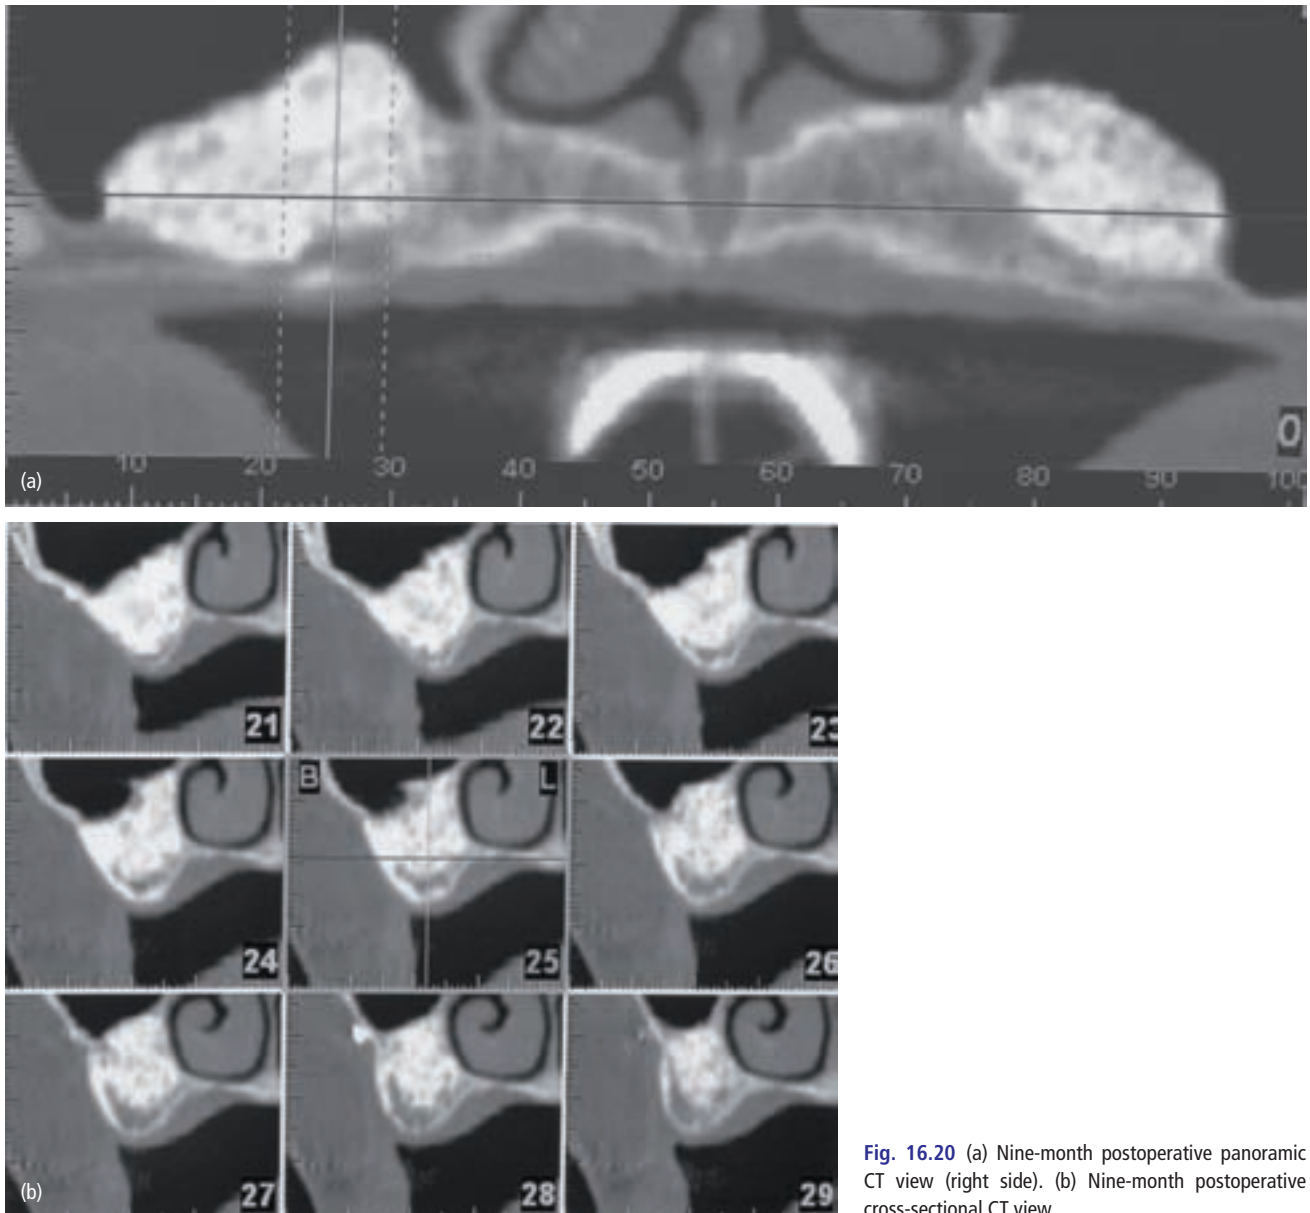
(a) Nine-month postoperative panoramic CT view (right side). (b) Nine-month postoperative cross-sectional CT view.
